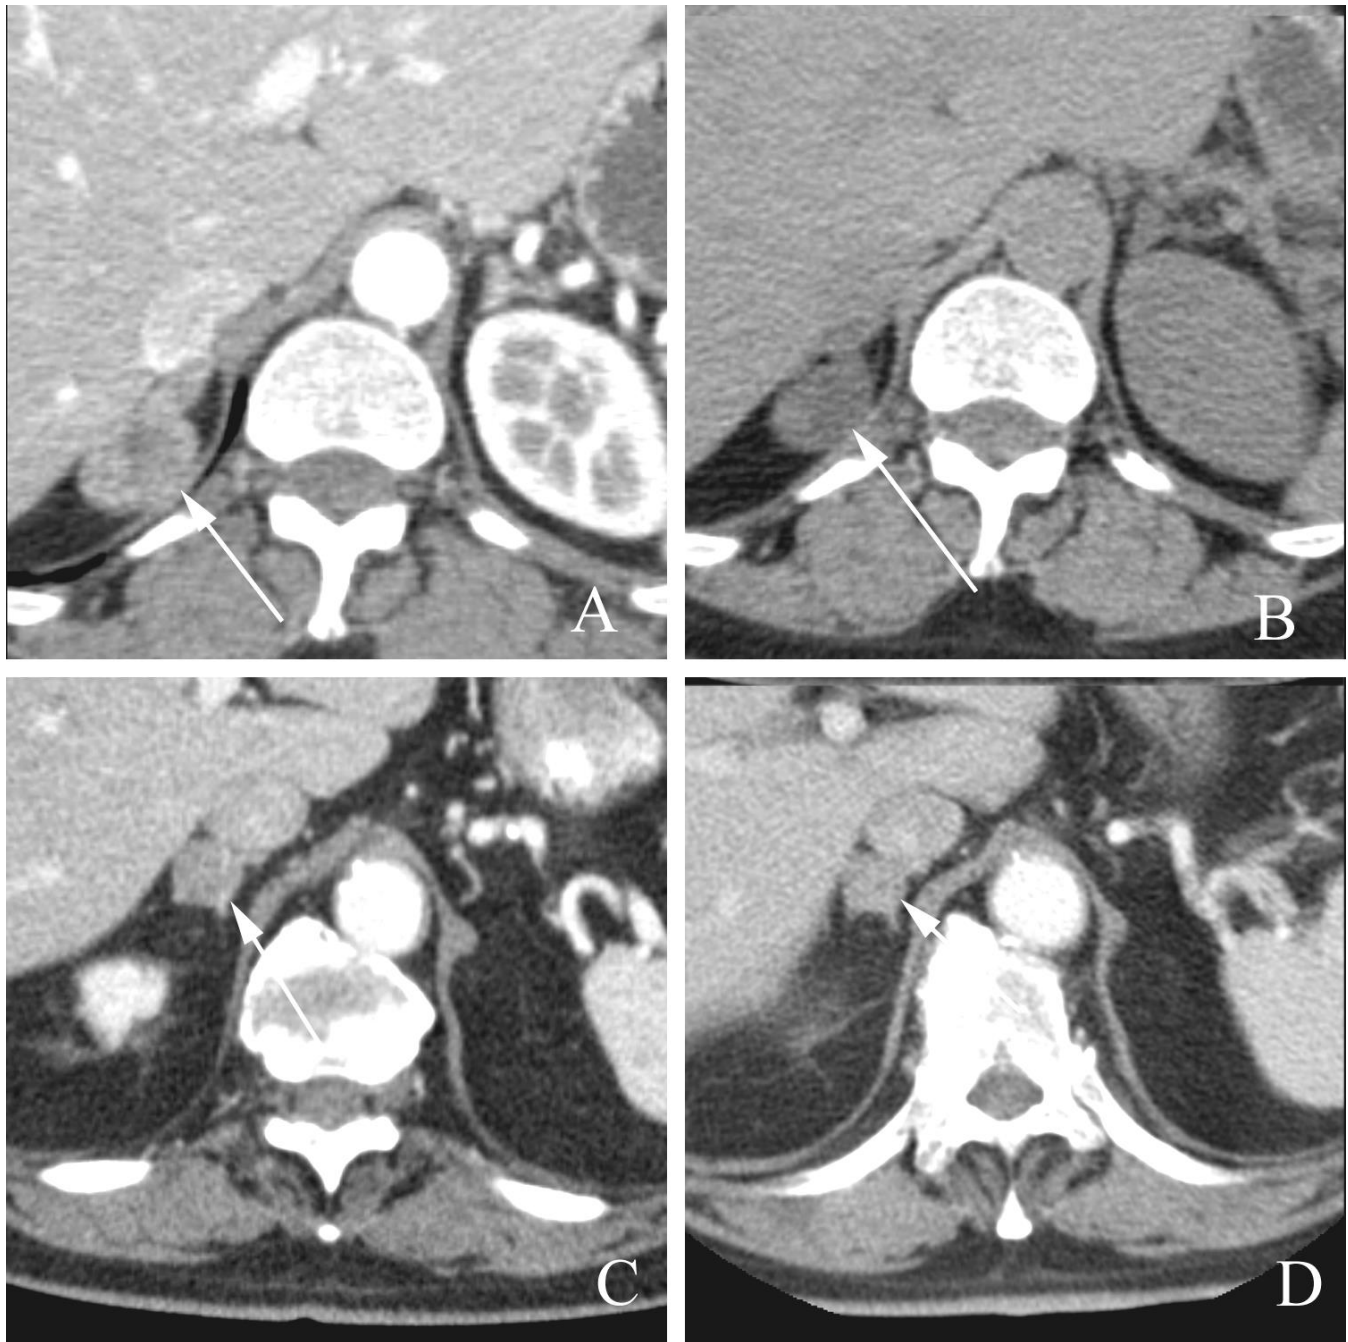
Adrenal incidentalomas where additional images demonstrated features of definitely benign adenoma. A. An axial CT done during the arterial phase of a CT performed for hematuria in a 60 year old woman shows a mass of the right adrenal (arrow). B. A noncontrast study performed at the same level shows the adrenal lesion to be hypodense ($HU < 0$), establishing the diagnosis as a benign adenoma. C. An axial CT done during work-up for esophageal carcinoma in a 78 year old man shows an adrenal lesion (arrow). D. Comparison with a study done eight years earlier shows that the lesion has undergone no interval change, diagnostic of a benign adrenal adenoma.
